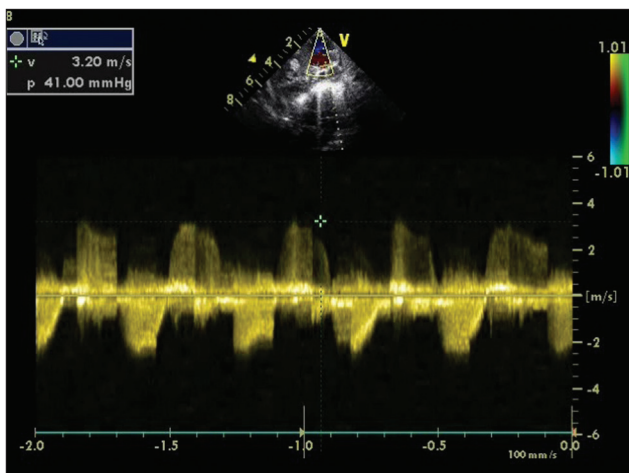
Doppler echocardiography showing pulmonary regurgitation
